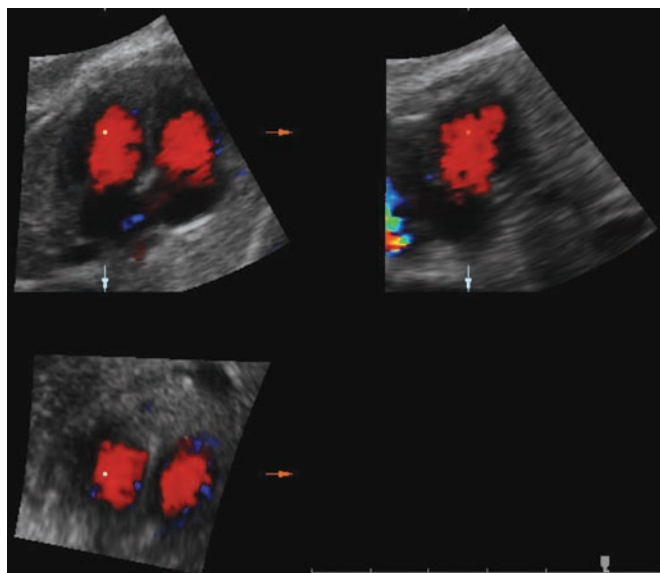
Fetal heart at 36 weeks. The STIC technique combined with color Doppler displays blood flow in all three orthogonal planes at the same time.
